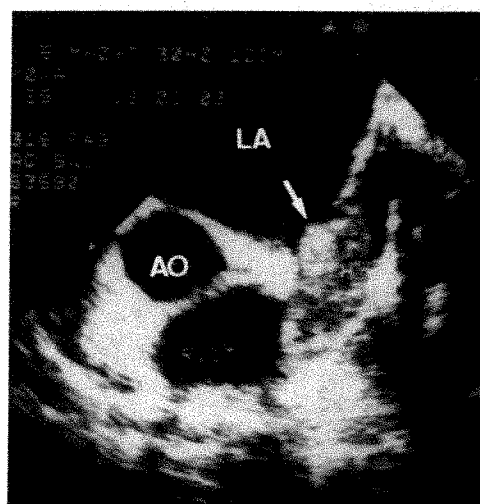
Transesophageal echocardiography showing small and fixed thrombus (TH) located at left atrial appendage. Patient underwent successful percutaneous transvenous mitral commissurotomy after giving informed consent. Other abbreviations as in Figure 1.
